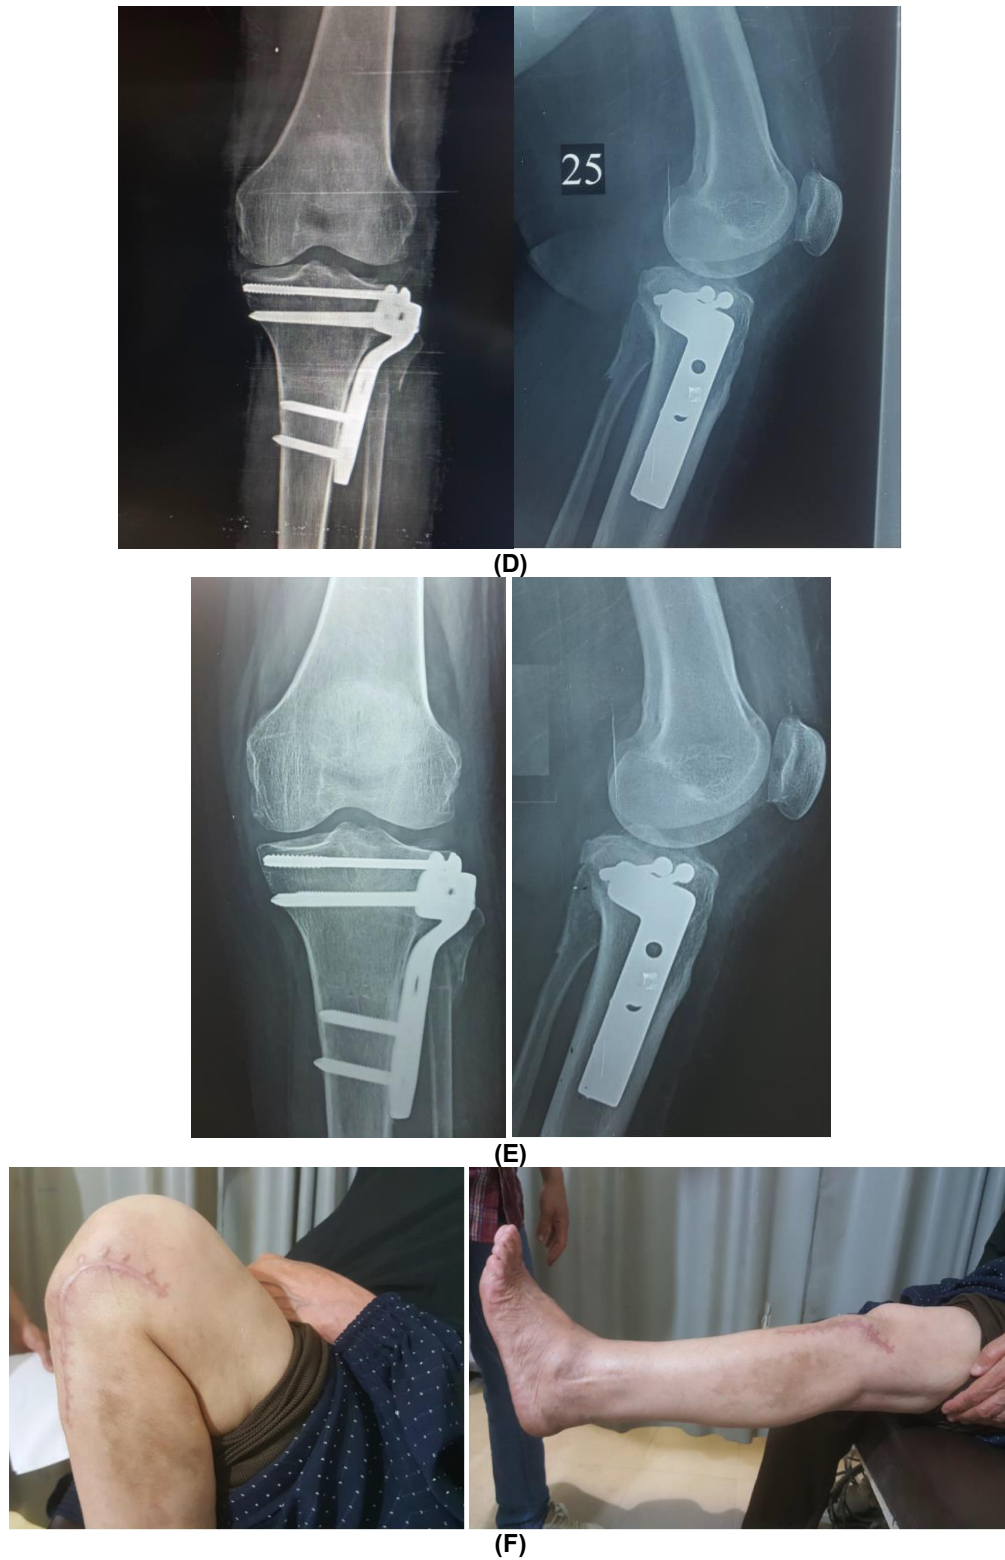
(A) Preoperative X-rays (B) Preoperative CT scan (C) Immediate postoperative X-ray (D) Three month follow up X-ray (E) Six month follow up X-ray (F)Six month postoperative maximum flexion & extension
